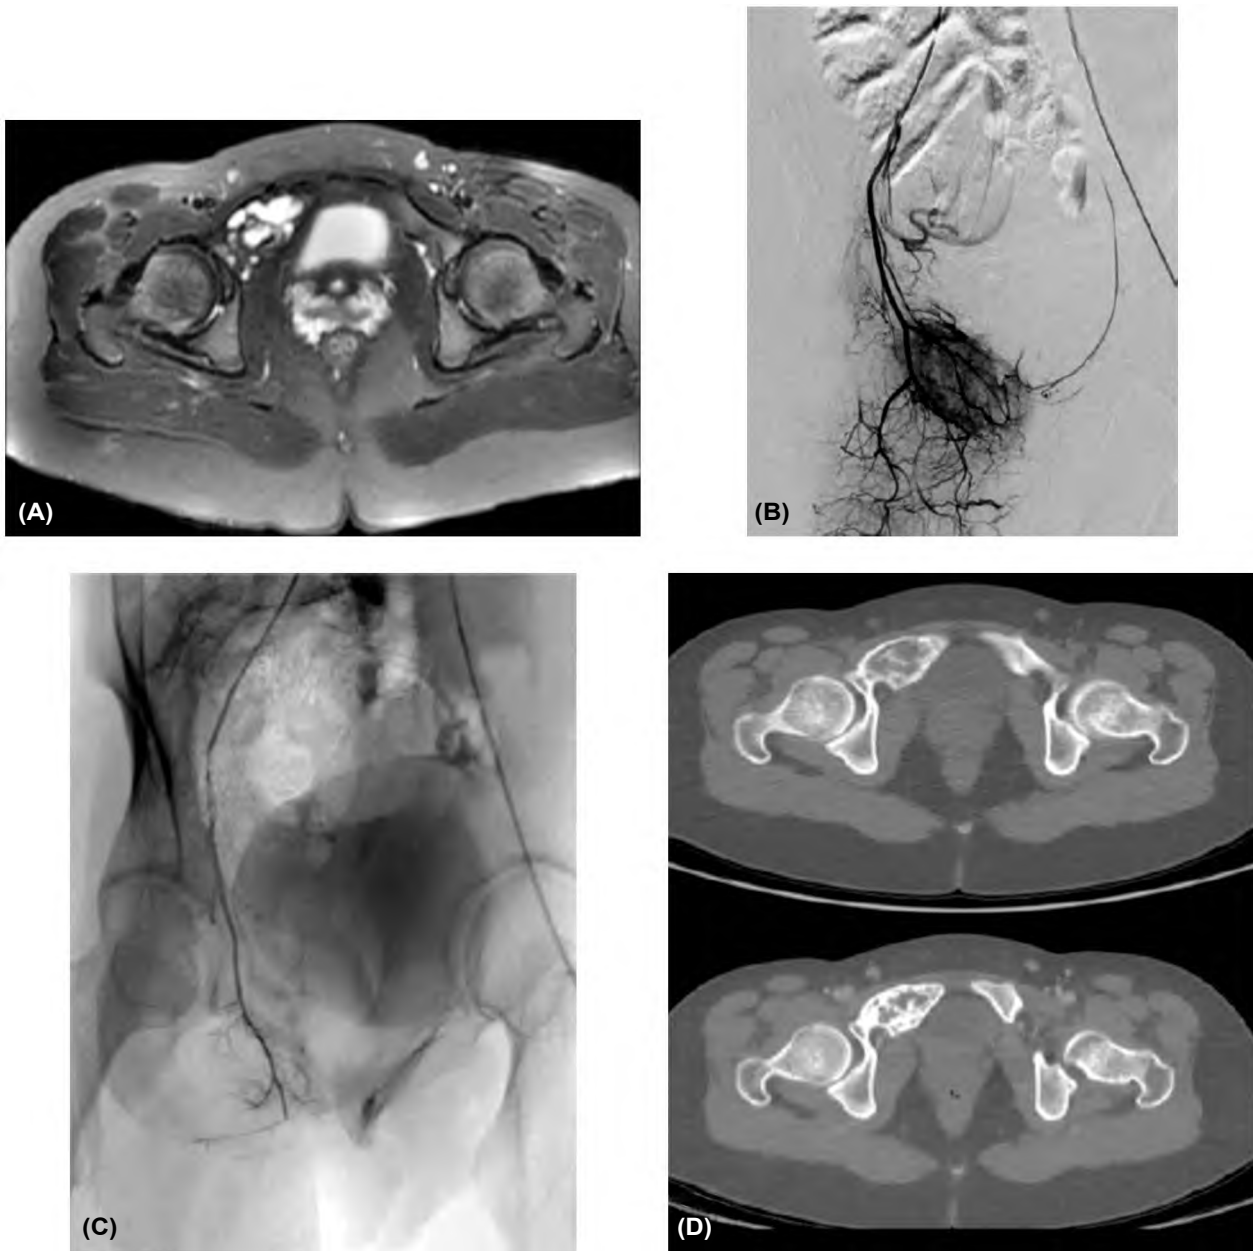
Female patient 17 years old with right pubic ABC. (A): MRI pelvis revealed multilocular right pubic bone benign looking lesion with fluid fluid levels on T2 (ABC). (B): Pre-embolization significant Tumor blush. C: Post-embolization no blush. (D): 6 months interval CT revealed significant increased sclerosis and mild regression in size.
